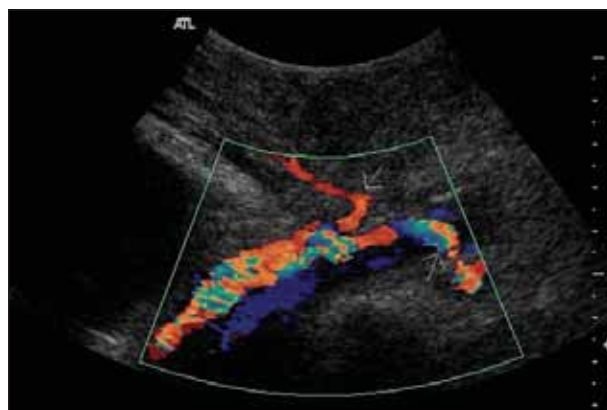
Color-flow Doppler imaging shows common femoral artery occlusion. Flow from the external iliac artery only goes into the inferior epigastric and circumflex iliac arteries.
